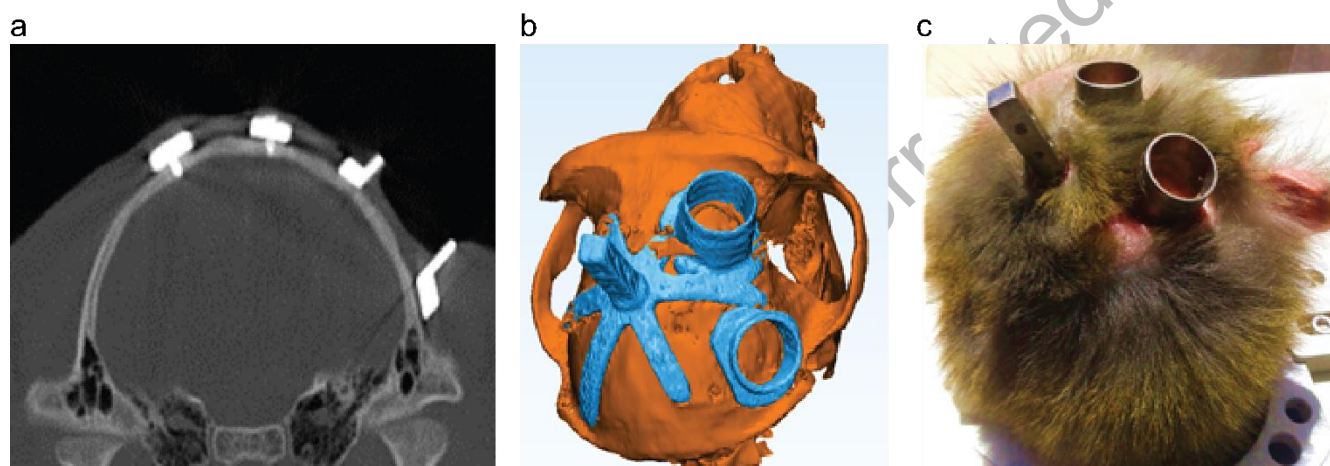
A CT scan imaging almost one year after surgery verified the location of implants a) Coronal section of CT it shows the depth of screw in the skull and coverage of skull tissue around the pedestals of headpost b) 3d model of skull with implants reconstructed based on CT scan image used to verification of the prearranged location of implants in models (c) One month after the operation the skin overs the implants were healthy and hairs raised around them.
